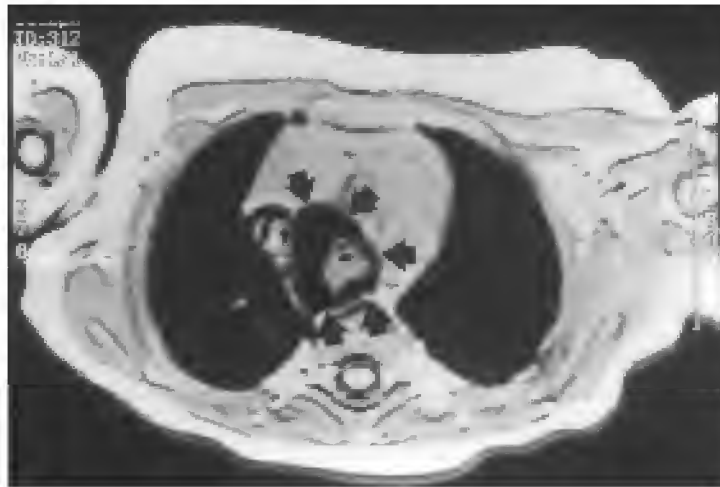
MRI demonstrating complete encirclement of the esophagus and trachea by a double aortic ring.
